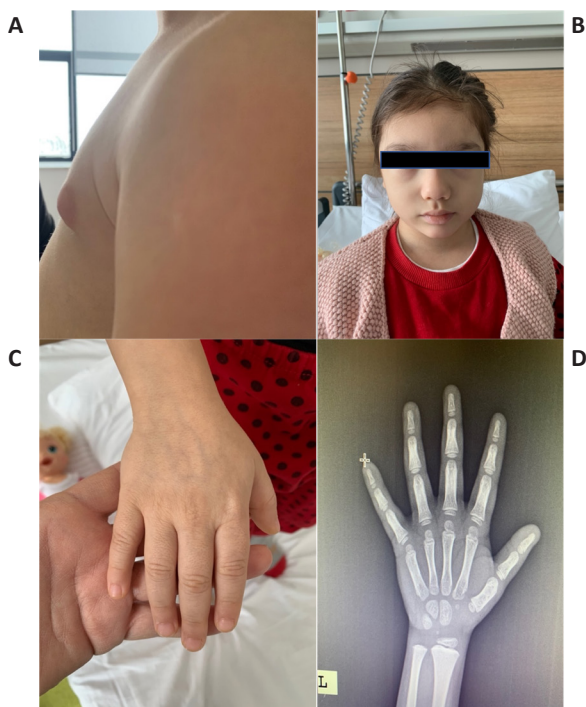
Clinical characteristics (A-C) and the X-ray of the patient's left hand showing delayed bone age (D)
